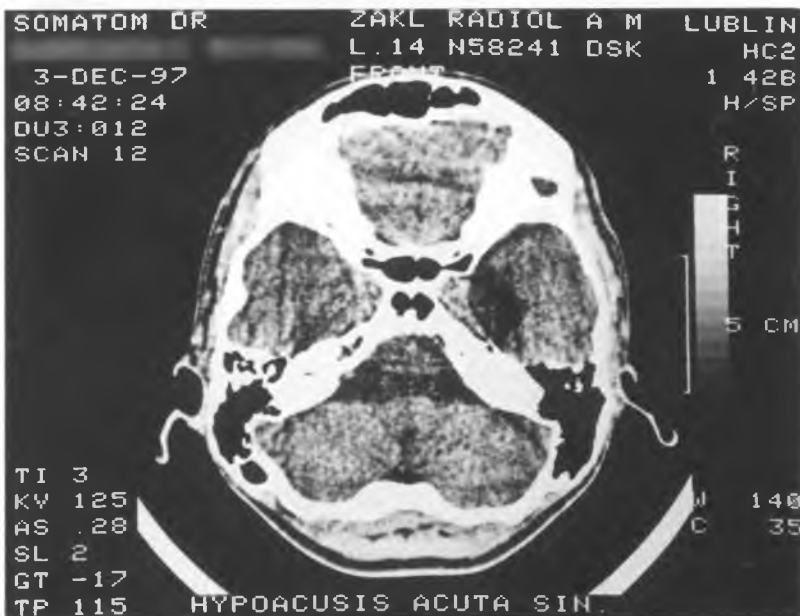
CT of the head just after the stroke
